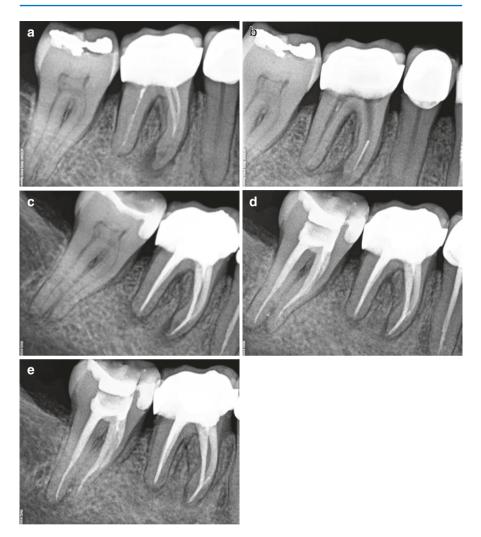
(a) Preoperative radiograph of a first mandibular molar with incomplete RCT and apical periodontitis. (b) Radiograph with a fragment in the apical third of the mesiobuccal canal fractured during retreatment procedure. (c) Immediate post-obturation radiograph following bypassing of the fragment, instrumentation up to the desired length, and dressing of the root canal with Ca(OH)₂ for 2 weeks. (d, e) Recall radiograph at 8 and 21 months, respectively, shows healing (Courtesy of Prof. J. Molyvdas)
